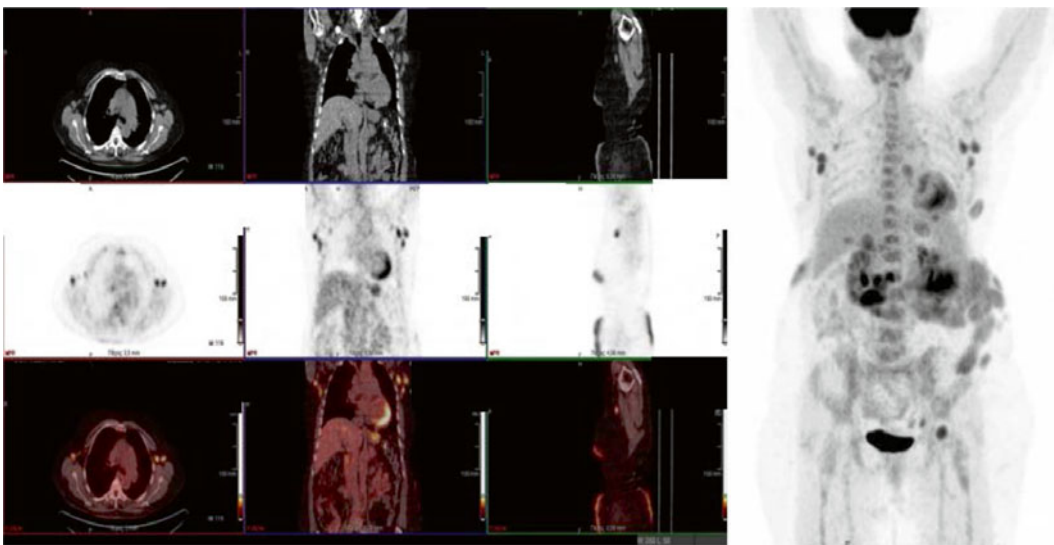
CT (upper row), PET (middle row), fused PET/CT (lower row), and MIP-PET images: multiple hypermetabolic lymph nodes at the axillary area bilaterally and the left inguinal region
